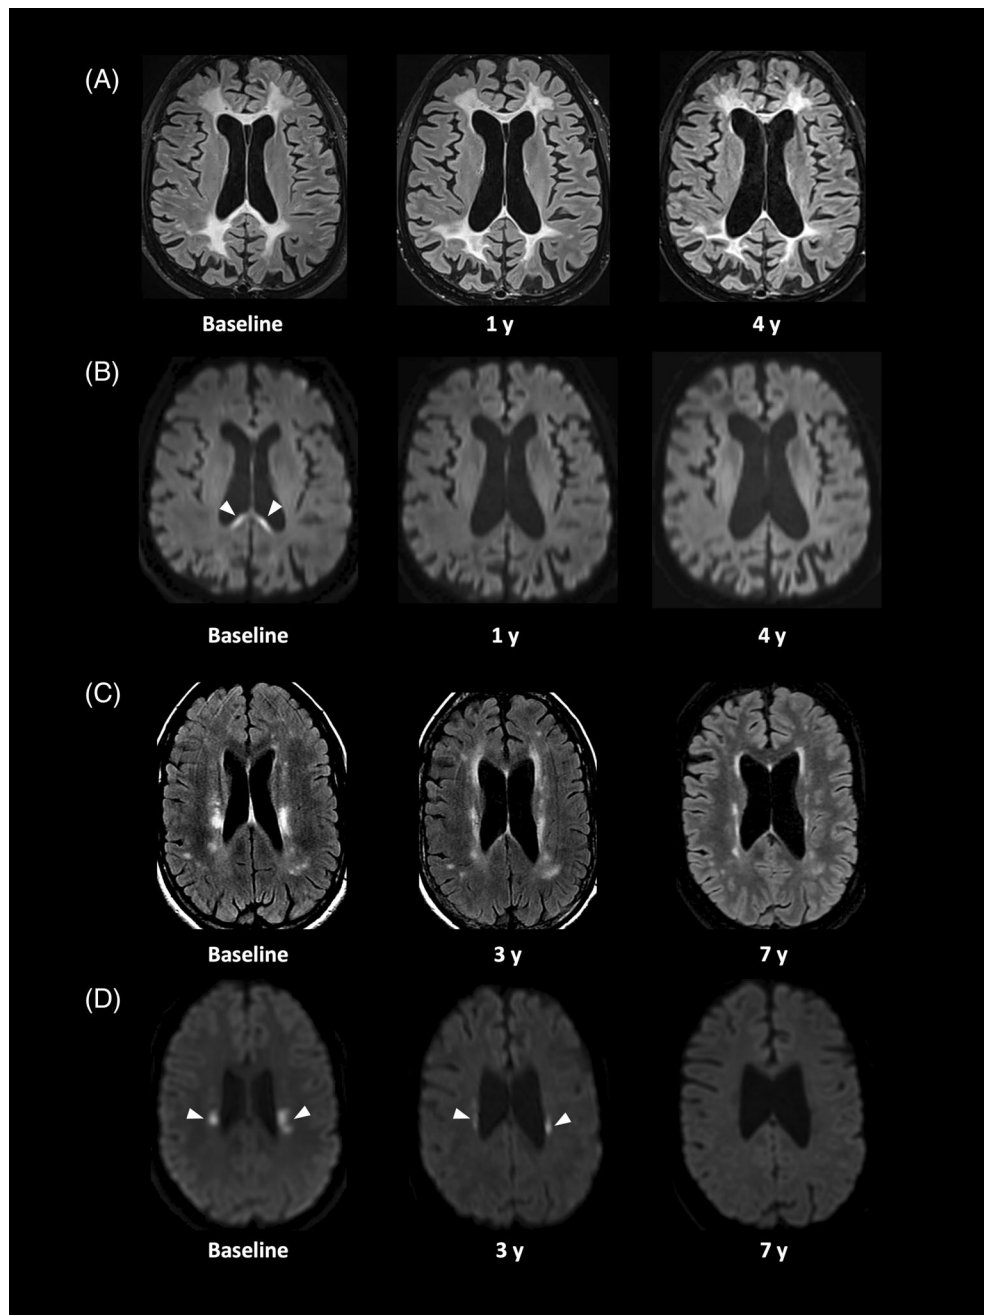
Changes in white matter lesions in CSF1R-RD patients with transplantation. (A) Patient-14 presented with extensive fluid-attenuated inversion recovery (FLAIR) hyperintensities in the frontal and parietal white matter at baseline. Lesions decreased in size from 1 year onwards after transplantation, in parallel with atrophic evolution. (B) Diffusion weighted imaging (DWI) of the same patient, exhibiting restricted diffusion in callosal lesions at baseline, that disappeared early after transplantation. (C) Patient-13 presented with areas of FLAIR hyperintensity in the centra semiovalia at baseline. Lesions progressively decreased in thickness and extent over a period of 7 years, in parallel with atrophic evolution. (D) DWI of the same patient, exhibiting restricted diffusion in lesions of the centra semiovalia at baseline. Diffusion abnormalities progressively decreased over time and disappeared at 7 years post-HSCT.
